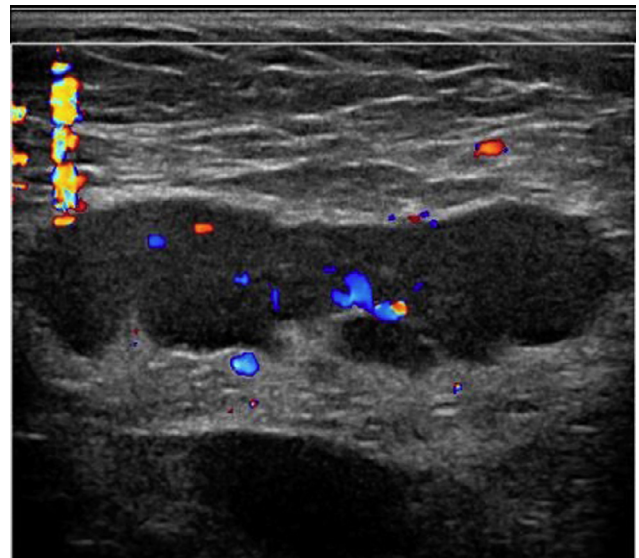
Ultrasound exam of right axilla with color Doppler. Increased color flow within the enlarged lymph node represents increased vascularity.
